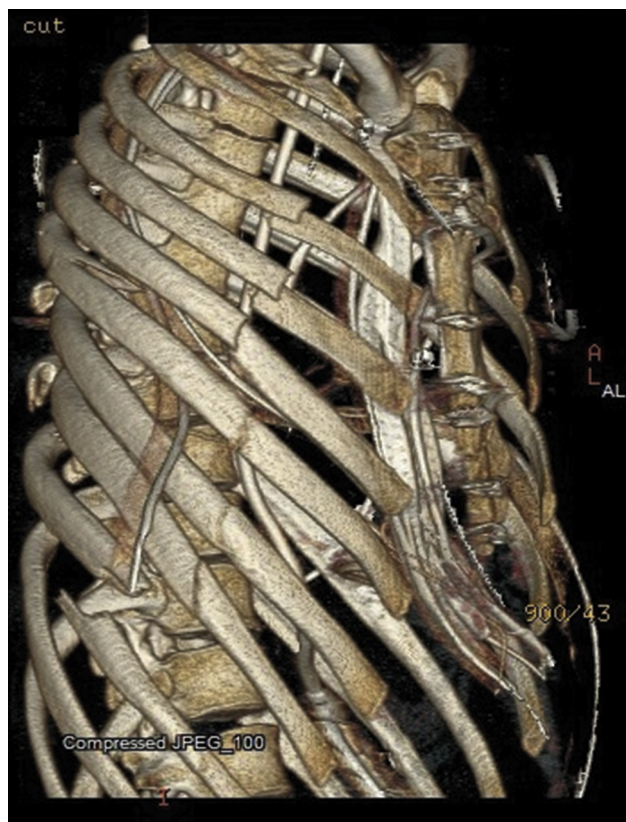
Right lateral three-dimensional computed tomography image of the chest wall with associated rib fractures.
